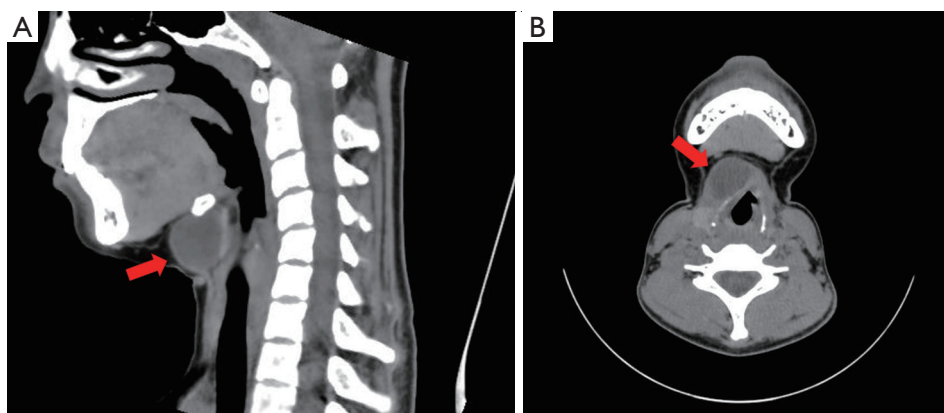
CT neck imaging. (A) A sagittal image obtained after 3D reconstruction can clearly show the relationship between the thyroglossal duct cyst (red arrow) and adjacent tissues. (B) The thyroglossal duct cyst (red arrow) is shown in the axial plane. CT demonstrated low density on the right hyoid bone with the size of 27 mm × 18 mm × 26 mm. CT, computed tomography; 3D, three-dimensional.
